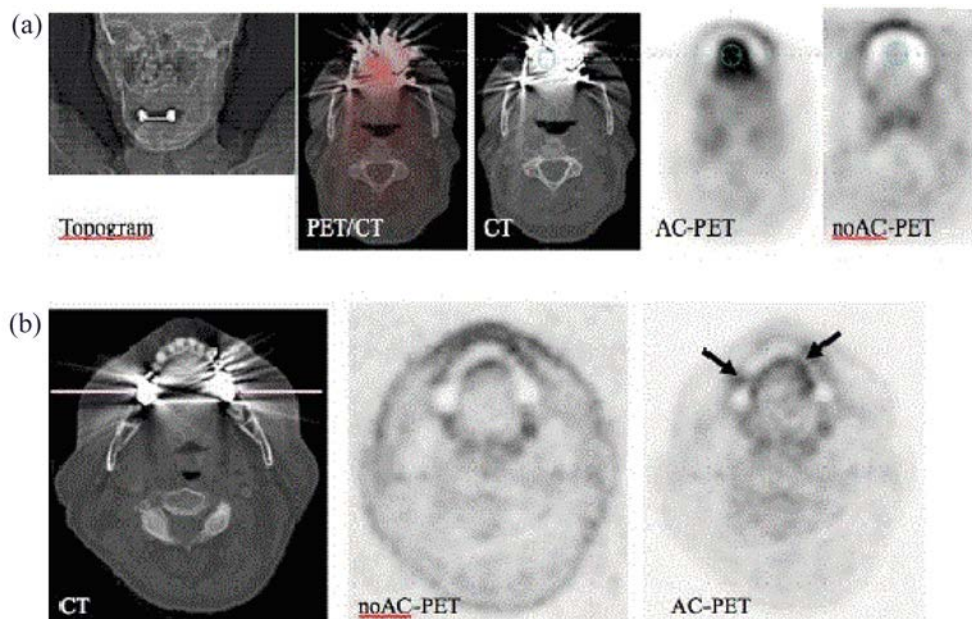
(a) Image appearance of bilateral dental fillings on the CT topogram, fused AC-PET/CT, CT, AC-PET and noAC-PET. It should be noted that, without patient motion, dental fillings do not propagate into artefactual tracer uptake on AC-PET. (b) Axial images through the mandible of a patient with bilateral dental implants: CT, noAC-PET and AC-PET. Owing to motion-induced misalignment of the CT and PET data, a bilateral focally increased tracer uptake was generated on AC-PET (arrows). AC: attenuation corrected; noAC: not attenuation corrected.
